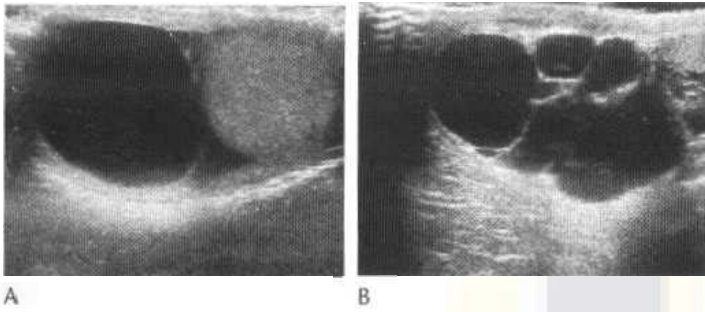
Ultrasound showing (A) a classical echo-free well-defined thin-walled solitary epididymal cyst and (B) a cluster of simple cysts.
